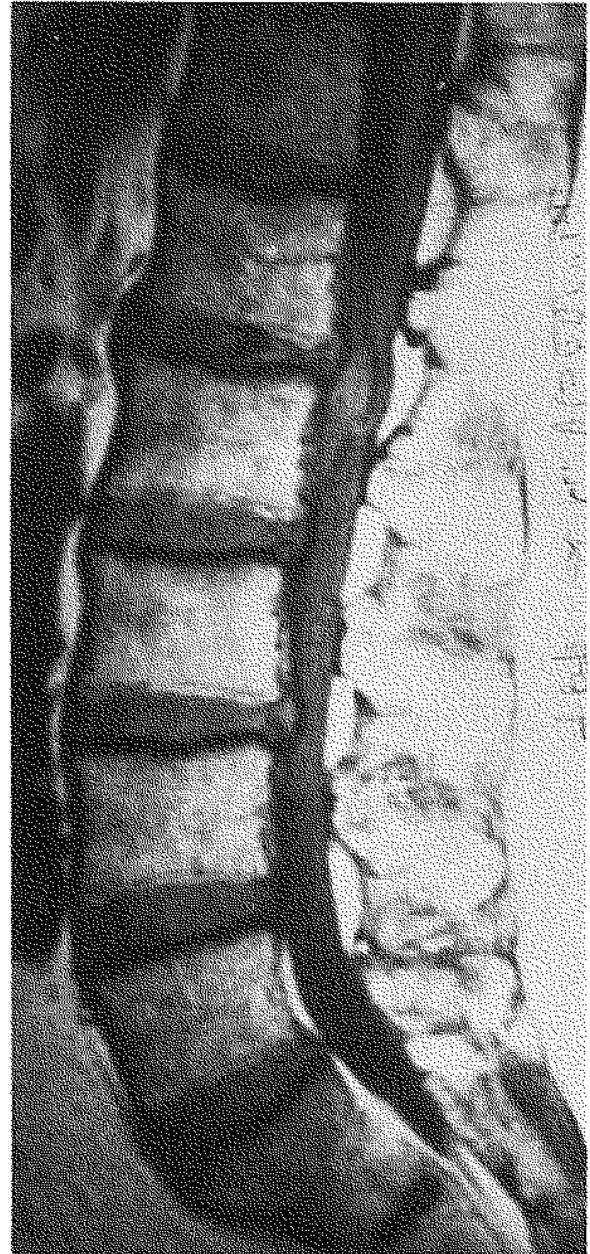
T1-weighted image (1,5 Tesla, Tr = 460 msec, Te = 20 msec) showing both disc herniations. The remaining intervertebral disc at the L1-L2 level shows signs of severe degeneration. The herniation itself has slid behind L2.
